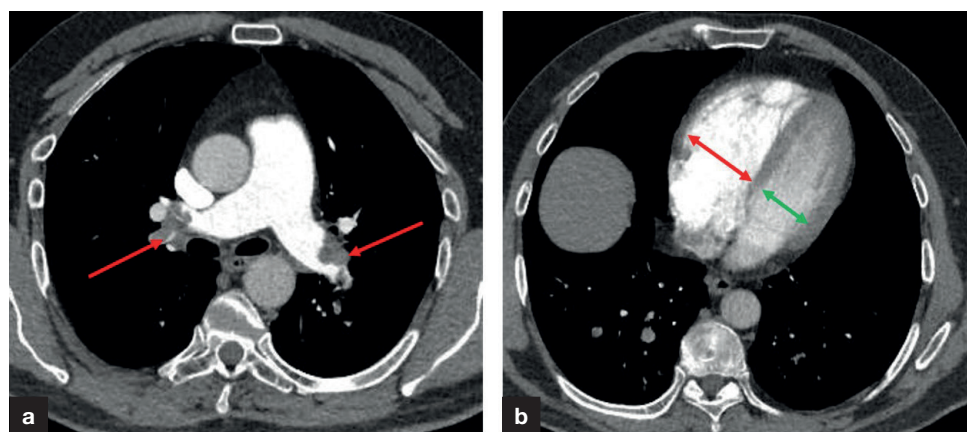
Computed tomography pulmonary angiogram showing (a) bilateral pulmonary emboli with (b) evidence of right ventricular strain.
